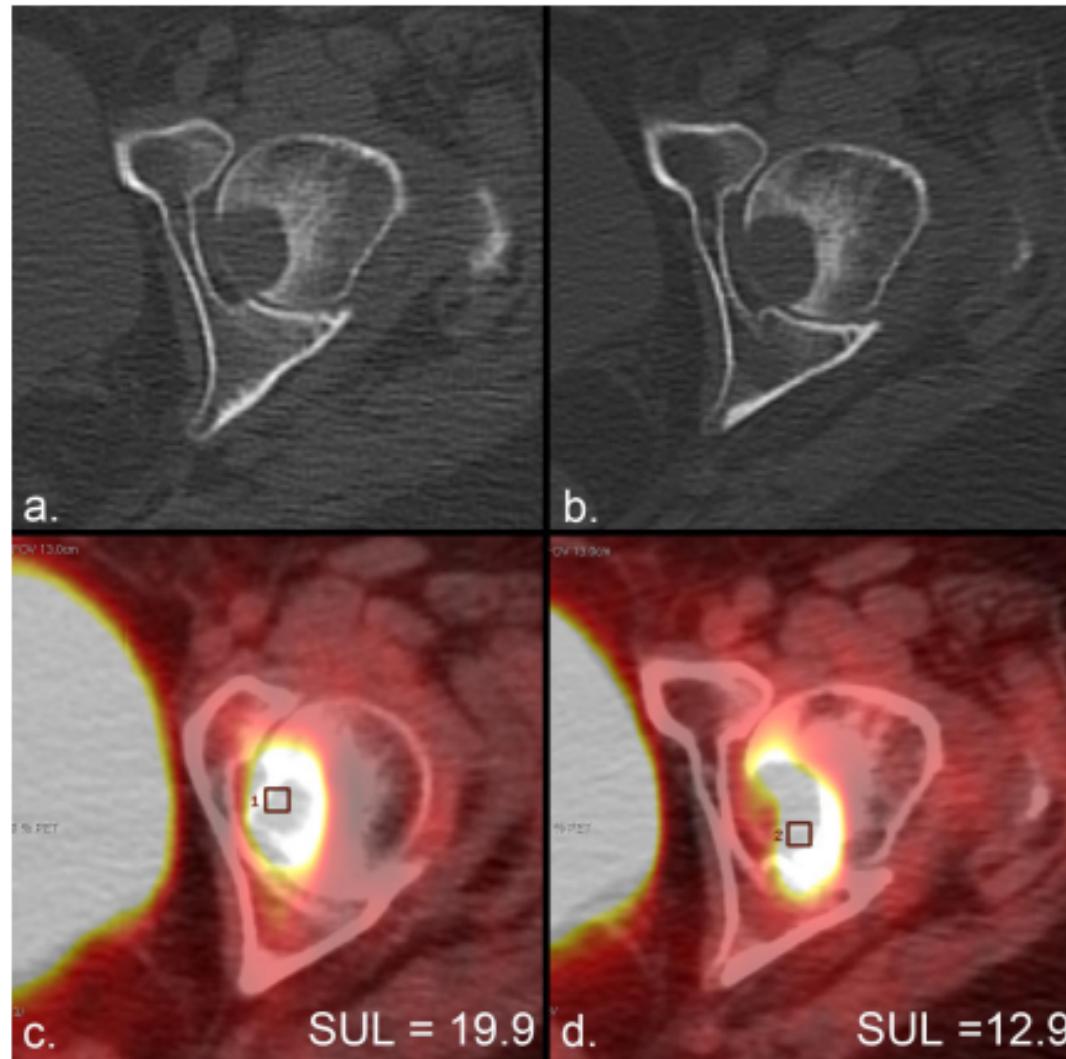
Metabolic response according to the PERCIST criteria in the absence of anatomic response. (a) The CT portion of an FDG PET/CT scan in a patient with lung cancer demonstrates a lytic metastasis in the left femoral head. (b) The CT from a PET/CT scan 2 months later demonstrates no anatomic change. (c, d) The standardized uptake value corrected for lean body mass (SUL) peak (average SUL in a 1-cm³ region of interest centered at the most active part of each tumor) changes from (c) 19.8 to (d) 12.9, representing a 35% decrease that satisfies the minimal requirements for partial response (> 30%) according to PERCIST. Assessment of tumor metabolism allowed therapeutic response to be measured in the absence of any other indication of change.
